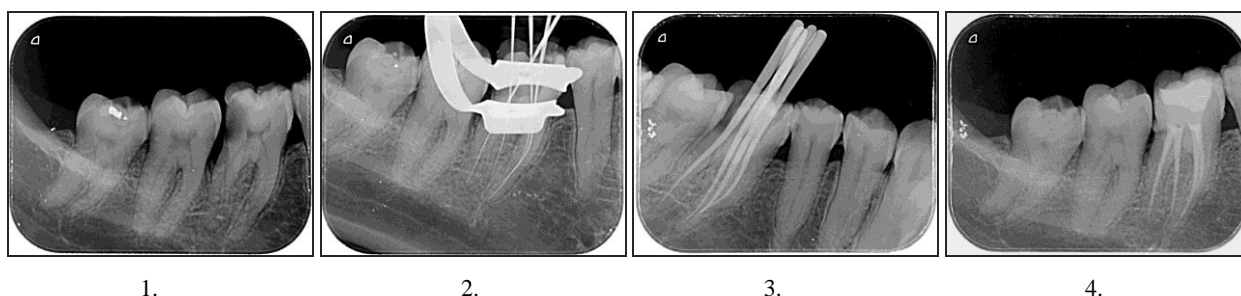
1. Preoperative radiograph of 46 2. Working length determination 3. Master cone 4. Completion of root canal treatment and permanent access restoration
